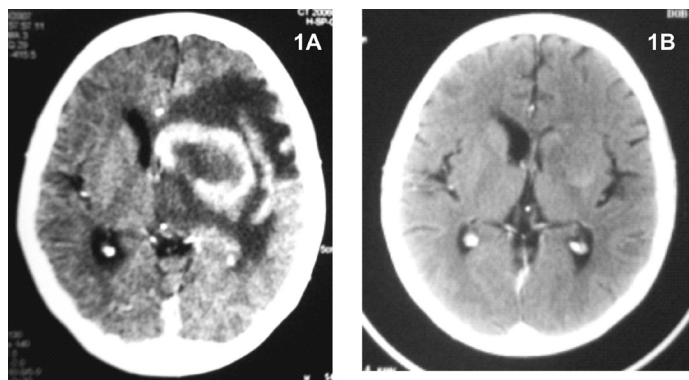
A) A computed tomography (CT) scan of the brain revealing an irregular, solitary large lesion in the left fronto-temporo-parietal region, with a thick ring-enhancing pattern and extensive perilesional edema. B) After two months of regular treatment with first-line antituberculous agents, a new CT scan showed important improvement of the lesion.
